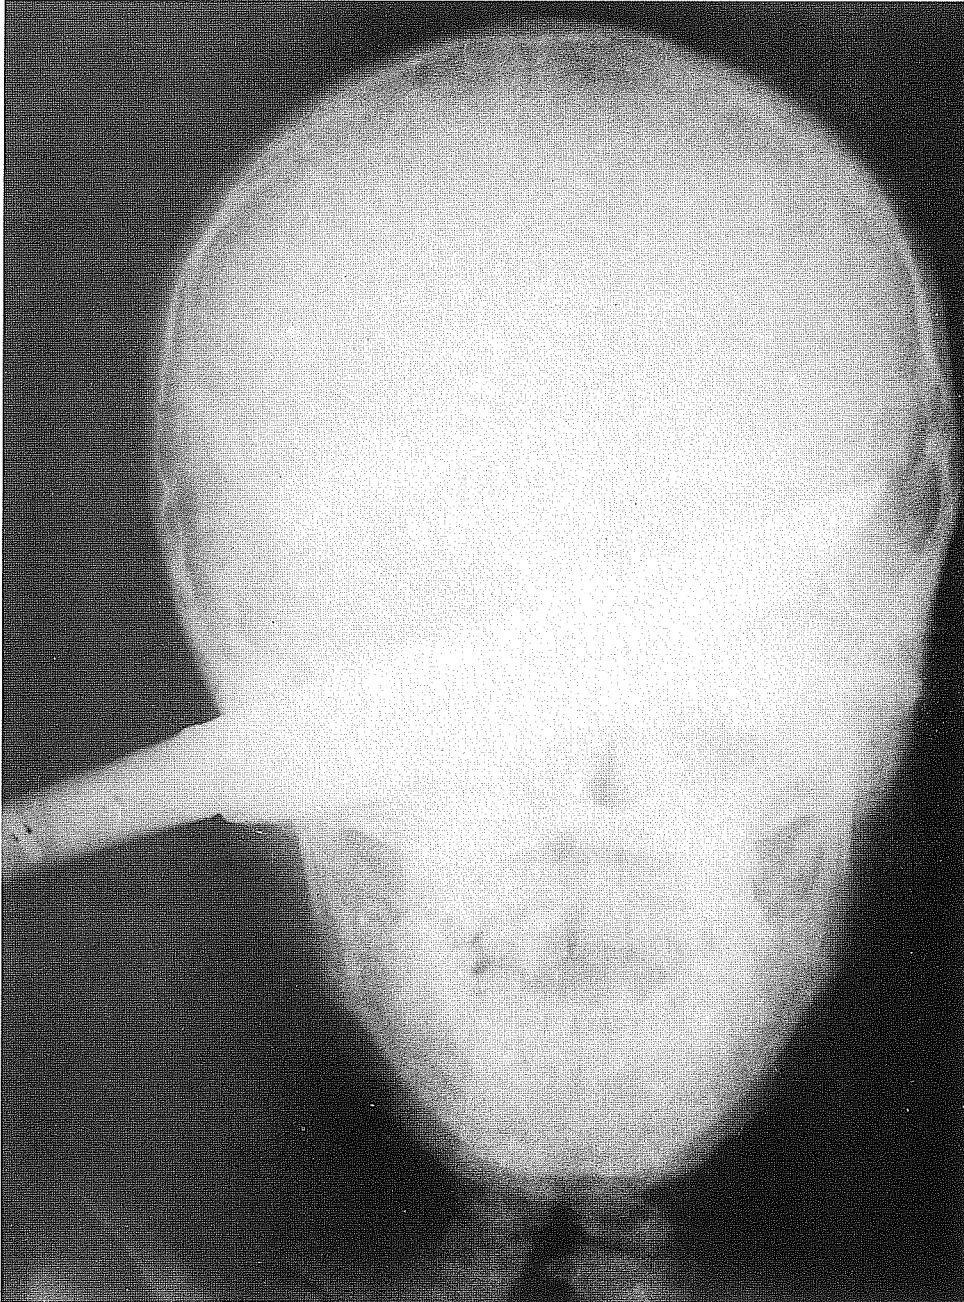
Preoperative PA X-ray of knife causing faciocranial stab wound
